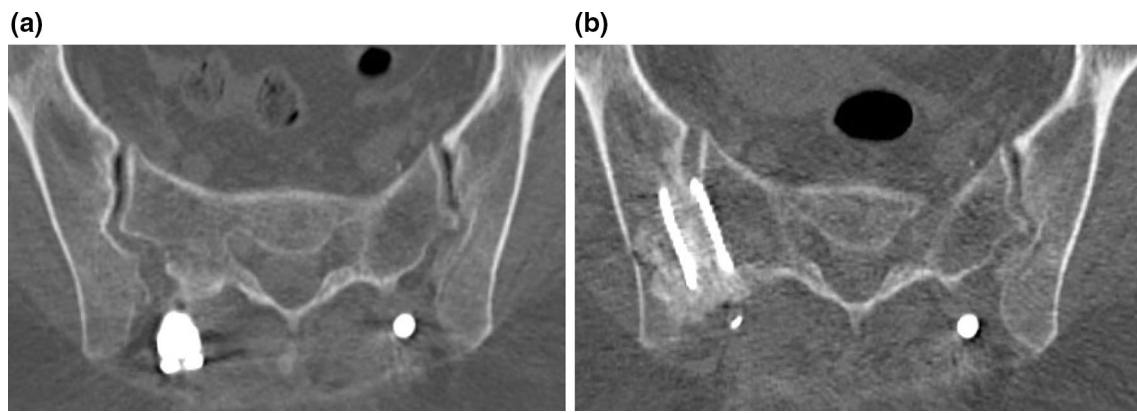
a Preoperative X-ray of severe left SIJ arthritis. b Postoperative X-ray with DIANA implant and distraction of left SIJ
